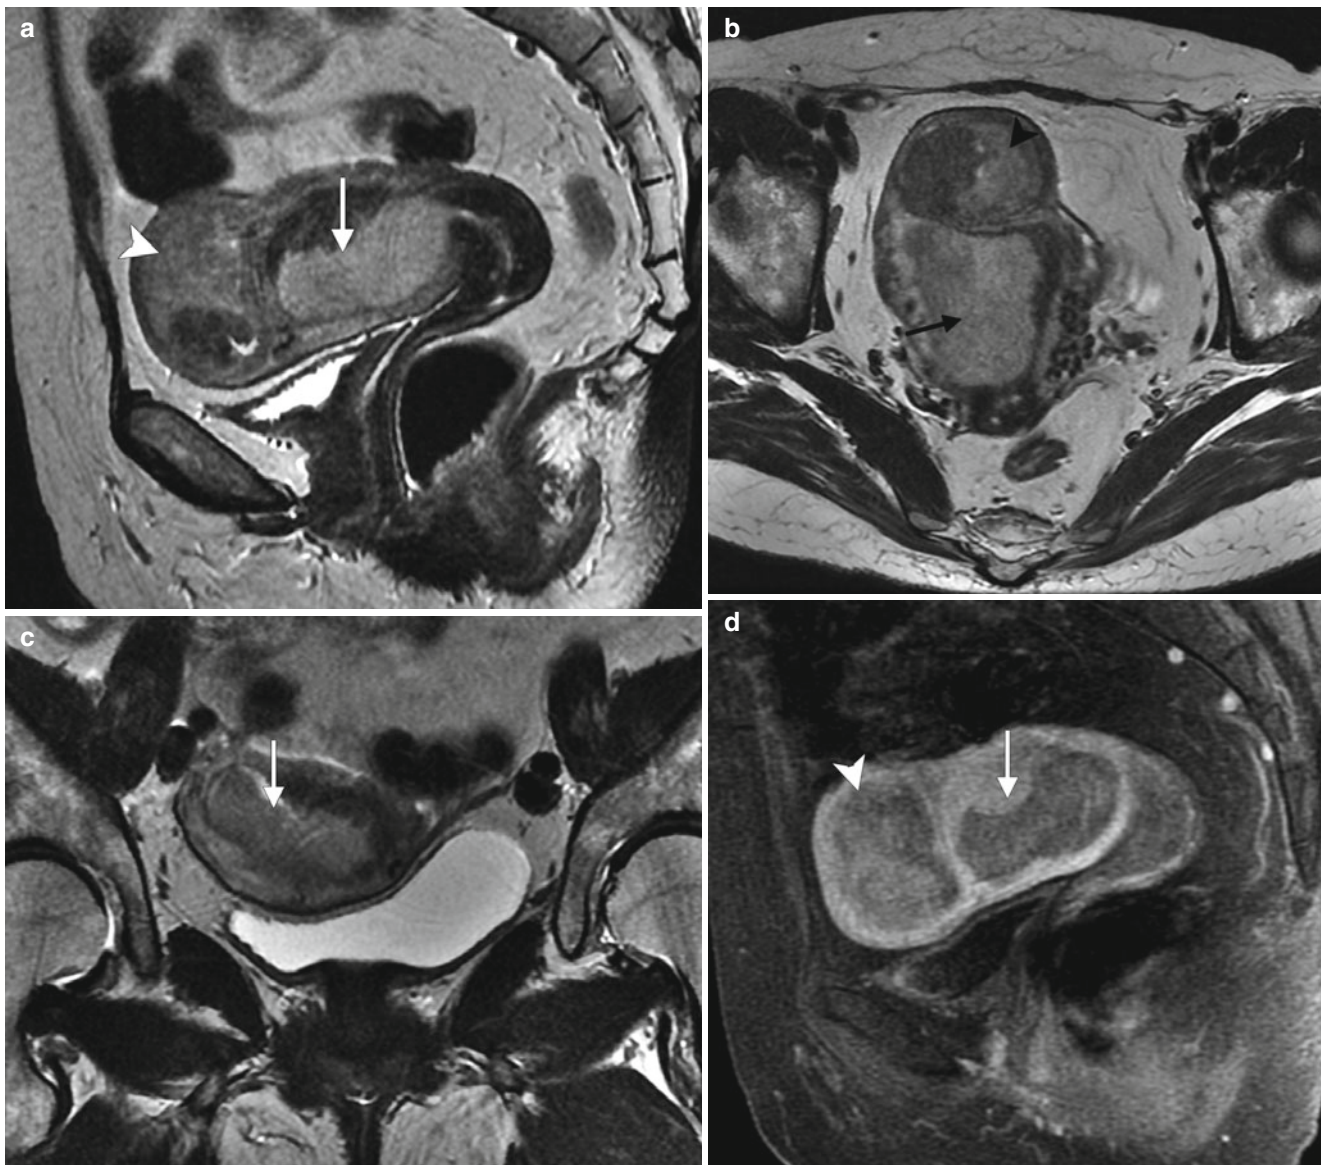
FIGO stage IB endometrial cancer in a 66-year-old woman presenting with postmenopausal vaginal bleeding. Sagittal (a), axial (b), and coronal (c) T2-weighted MR images and a sagittal, fat-suppressed T1-weighted image following intravenous gadolinium
